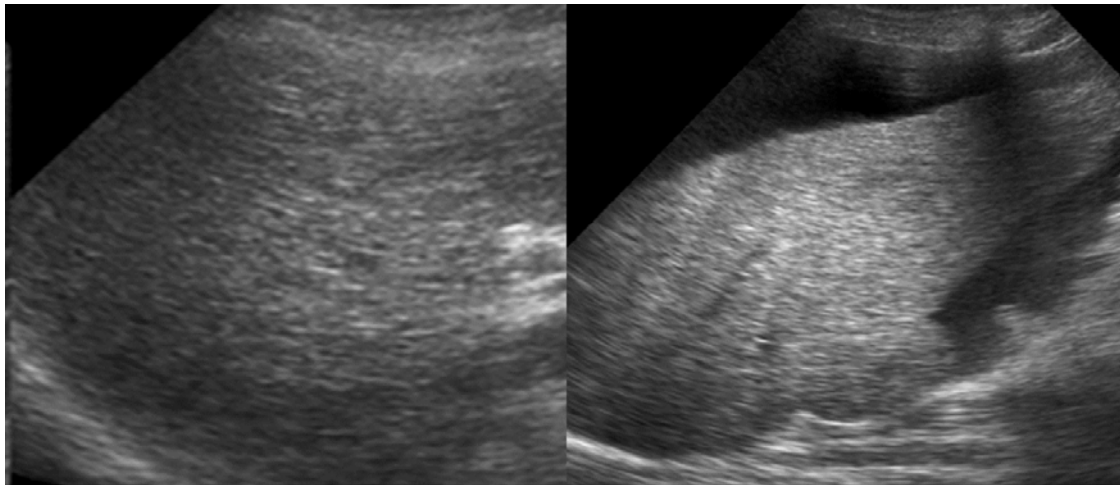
Conventional gray scale B-Mode liver ultrasound images with appearance of cirrhotic liver
